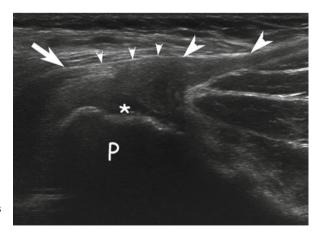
Acute grade III tear (complete tear) of the tendon of the adductor longus. Sonographic scans, transverse (a) and longitudinal (b), on the level of the proximal part of the adductor longus show hematoma (*asterisk*) in the space between adductor brevis (*ABrv*) and pectineus (*P*) muscles and retracted tendon stump of the avulsed adductor longus from the pubic tubercle (*arrows*). The same patient in transverse short tau inversion recovery (STIR) MR image and coronal T2-weighted image (c, d). Images show stump of the tendon surrounded by hematoma (*arrows*). On the left side, the normal tendon is clearly defined
